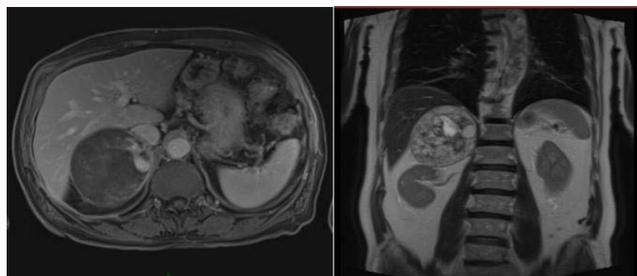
On the left, T1-weighted MRI showing a quiet homogeneous adrenal mass with spontaneous peripheral high signal intensity. A thin rim surrounds the lesion. On the right, T2-weighted MRI showing heterogeneous signal with highly vascularized nodular areas.
